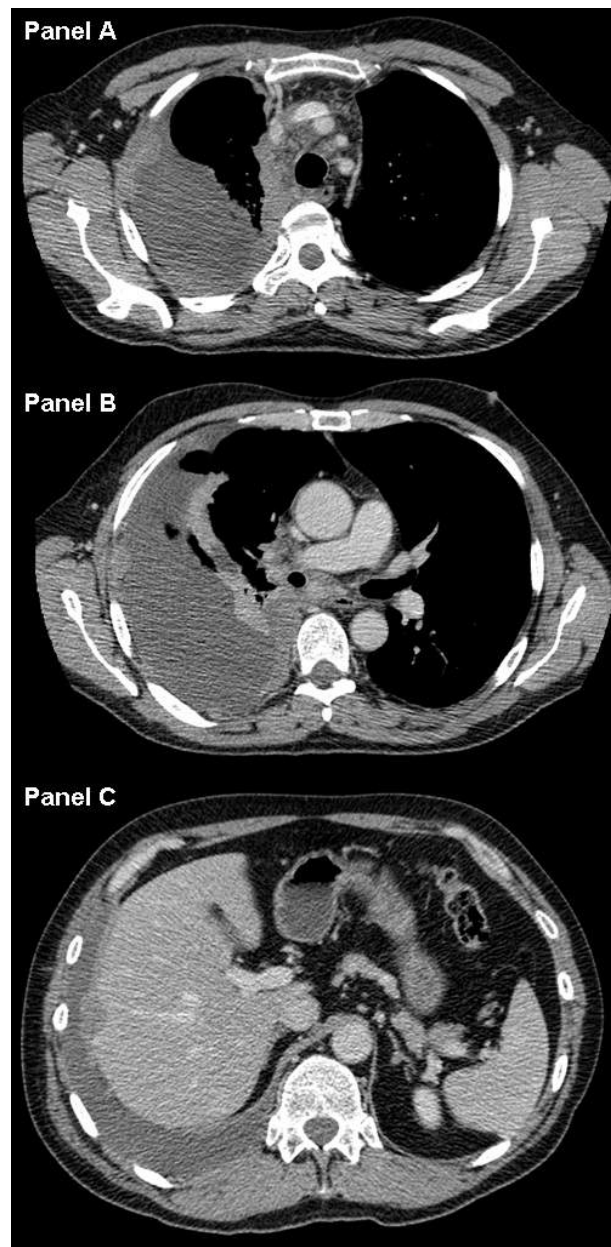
Axial contrast-enhanced CT images of a patient with MPM, taken at the Queen Elizabeth University Hospital 2015, demonstrating enhancing pleural mass lesions, nodular pleural thickening and mediastinal pleural thickening (Panels A and B) and infiltration of the diaphragm (Panel C).
